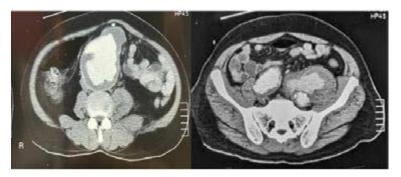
Patient's CT abdomen
